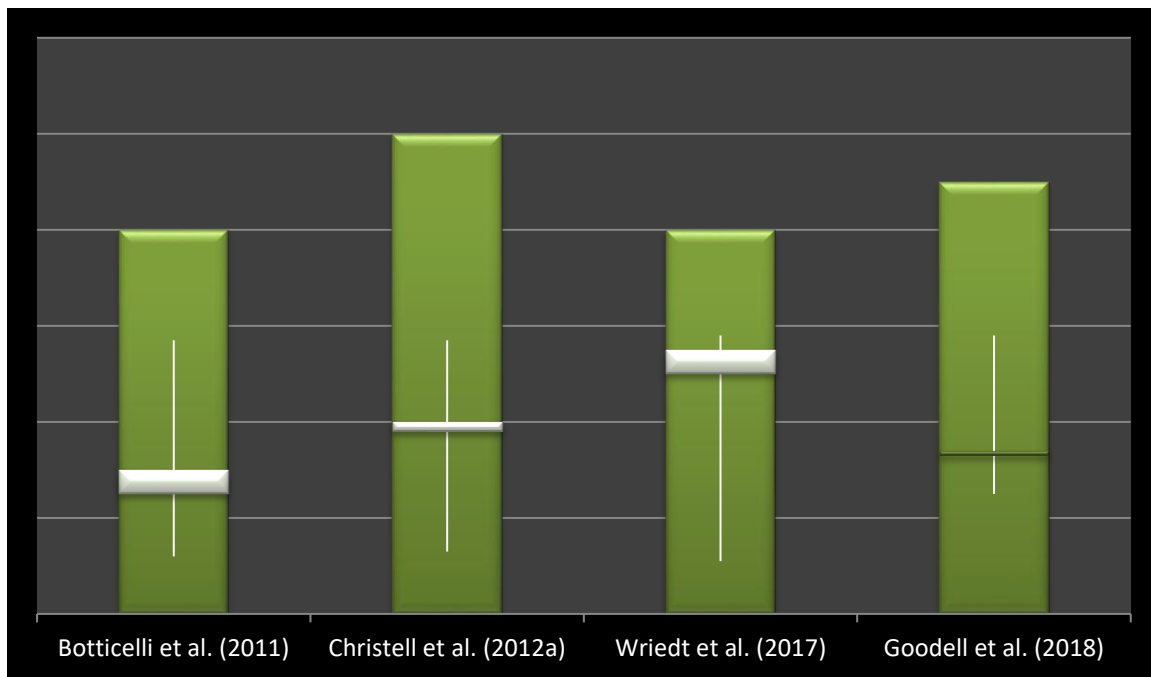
Box and whisker plot showing analysis of different studies for diagnostic efficacy of CBCT in paediatric patients
